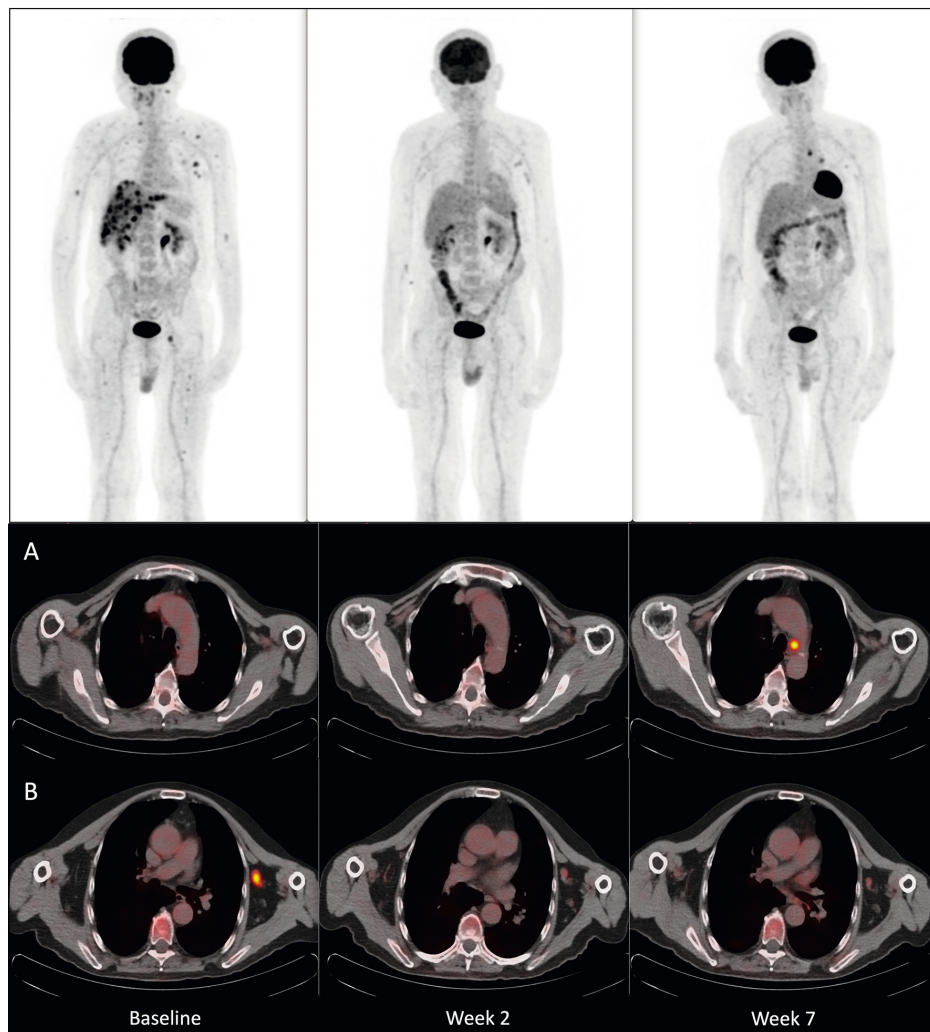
Maximum Intensity Projection and transaxial [^{18}F]FDG PET/CT at baseline (left), week 2 (middle) and week 7 (right). PET/CT at baseline shows multiple [^{18}F]FDG-avid metastases in lymph nodes (left axilla), liver and bone (right humerus, pelvis, left and right femur). All metastases show decreased [^{18}F]FDG uptake corresponding with response to treatment 2 weeks after initiation. At week 7, new [^{18}F]FDG-avid lymph nodes are shown subaortic (A) and left hilus, while other sites remain in complete metabolic remission (B).
